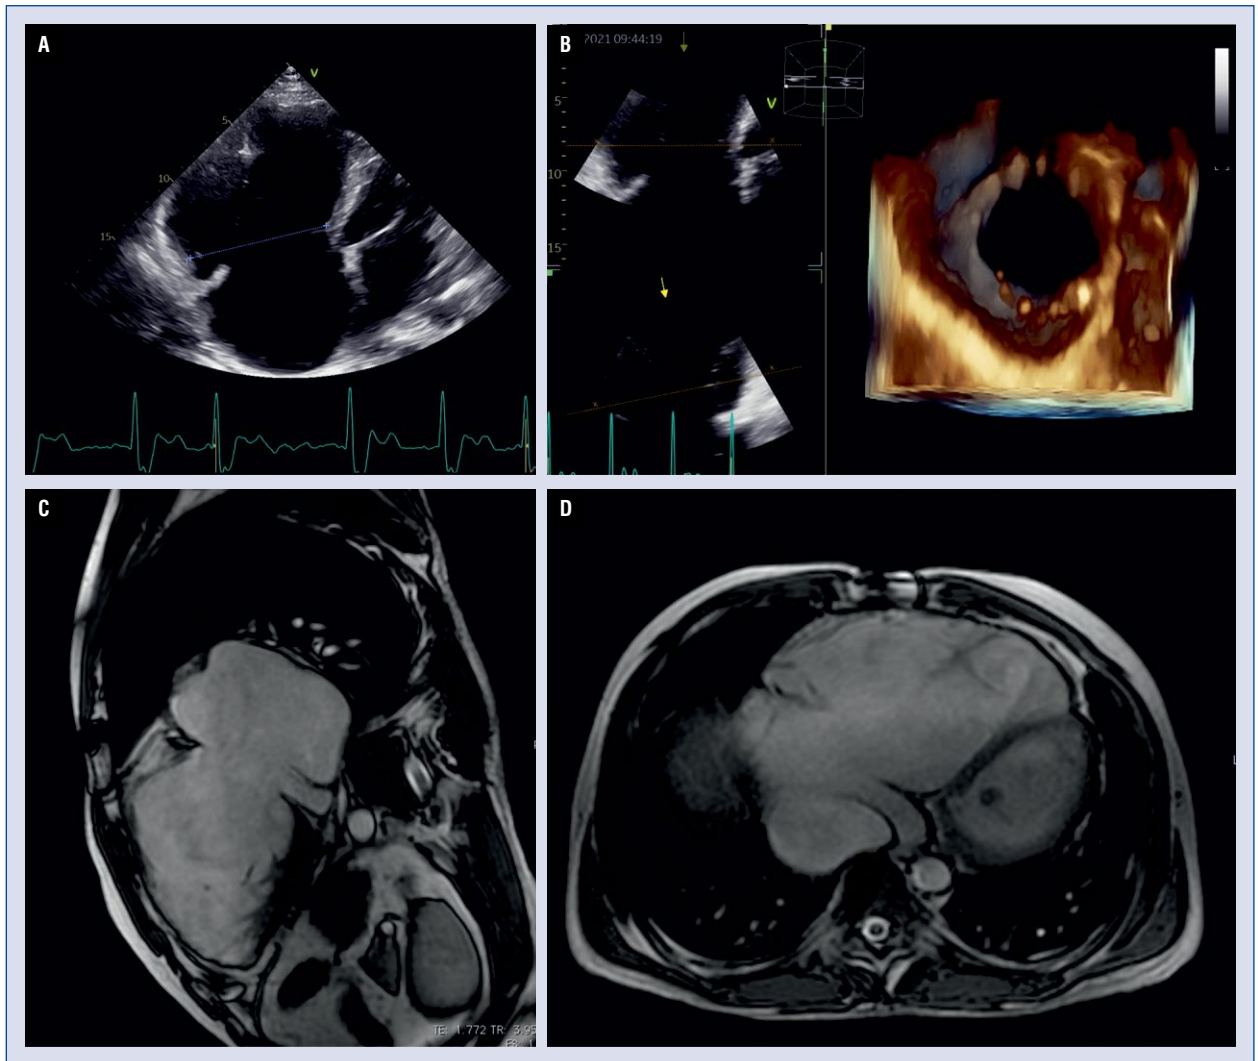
A. Transthoracic echocardiography. Apical four-chamber view. Enlarged right ventricle and right atrium. Right ventricle/left ventricle ratio > 1. Only small remains of the tricuspid valve leaflets are seen. Interatrial septum bows toward the left atrium; B. Three-dimensional echocardiographic imaging from a transthoracic approach. Fragments of the tricuspid valve seen from the right ventricle; C, D. Magnetic resonance imaging of the right heart (C: two-chamber view, D: four-chamber view).
